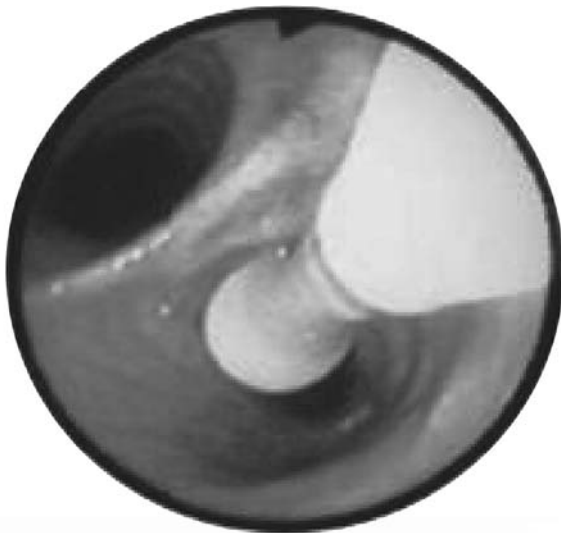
Left: Radial probe endobronchial ultrasound-guided transbronchial needle aspiration. Radial probe is placed in the endobronchial ultrasound (EBUS) bronchoscope working channel but must be removed prior to sampling. Right: the radial probe ultrasound image is 360 degrees to the long axis of the EBUS bronchoscope. LN#3: lymph node. Reproduced with permission of American College of Chest Physicians.⁵
